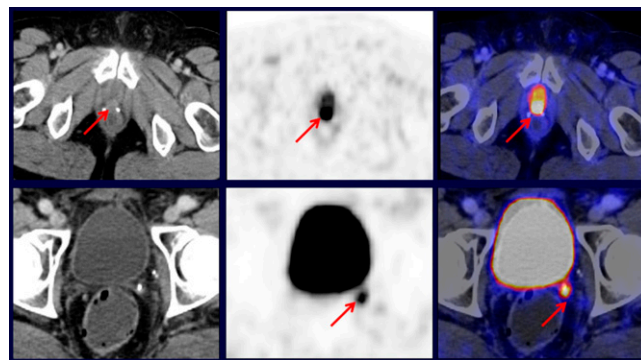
Examples of local prostate cancer recurrence imaged by ^{68}Ga -PSMA PET/CT. Top (left to right): CT, PET, and fusion imaging in a 46-year-old man; the diagnosis was made by PET and CT. Bottom (left to right): CT, PET, and fusion imaging in a 63-year-old man; the diagnosis was made by PET only.
